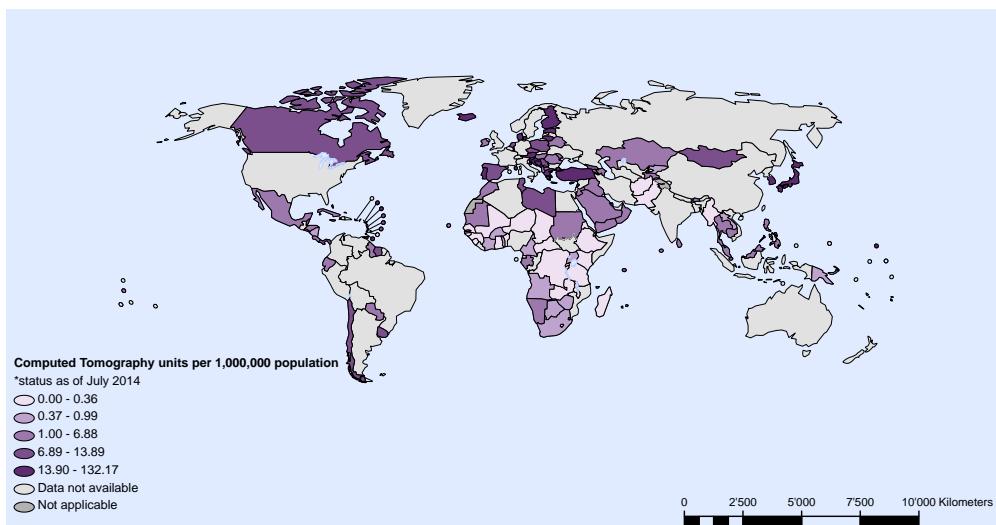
Computed Tomography (CT) units per million population. 2014. Data from Global Health Observatory (14).
